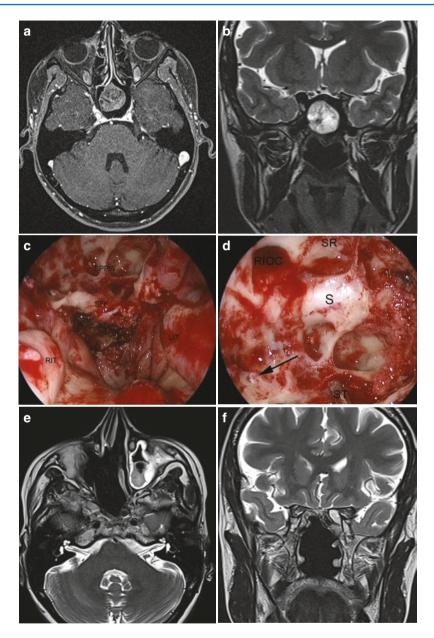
AdCC (mixed tubular-cribriform pattern of growth) involving the sphenoetmhoidal region with no evidence of perineural spread or intracranial extension at preoperative MRI evaluation on axial (a) and coronal plane (b). A transnasal endoscopic resection without craniectomy was planned; intraoperatively (c and d), no involvement of the Vidian nerve (arrow in d) and sphenoid bone was found. The patient underwent postoperative radiotherapy. MRI on axial (e) and coronal (f) planes shows no sign of local recurrence at 5 years after treatment. (*LIT* left inferior turbinate, *RIOC* right interoptic-carotid recess, *RIT* right inferior turbinate, *S* sellar region, *SFF* sphenoid sinus floor, *SR* sphenoid roof, *SSPW* sphenoid sinus posterior wall, *ST* suction tube)
